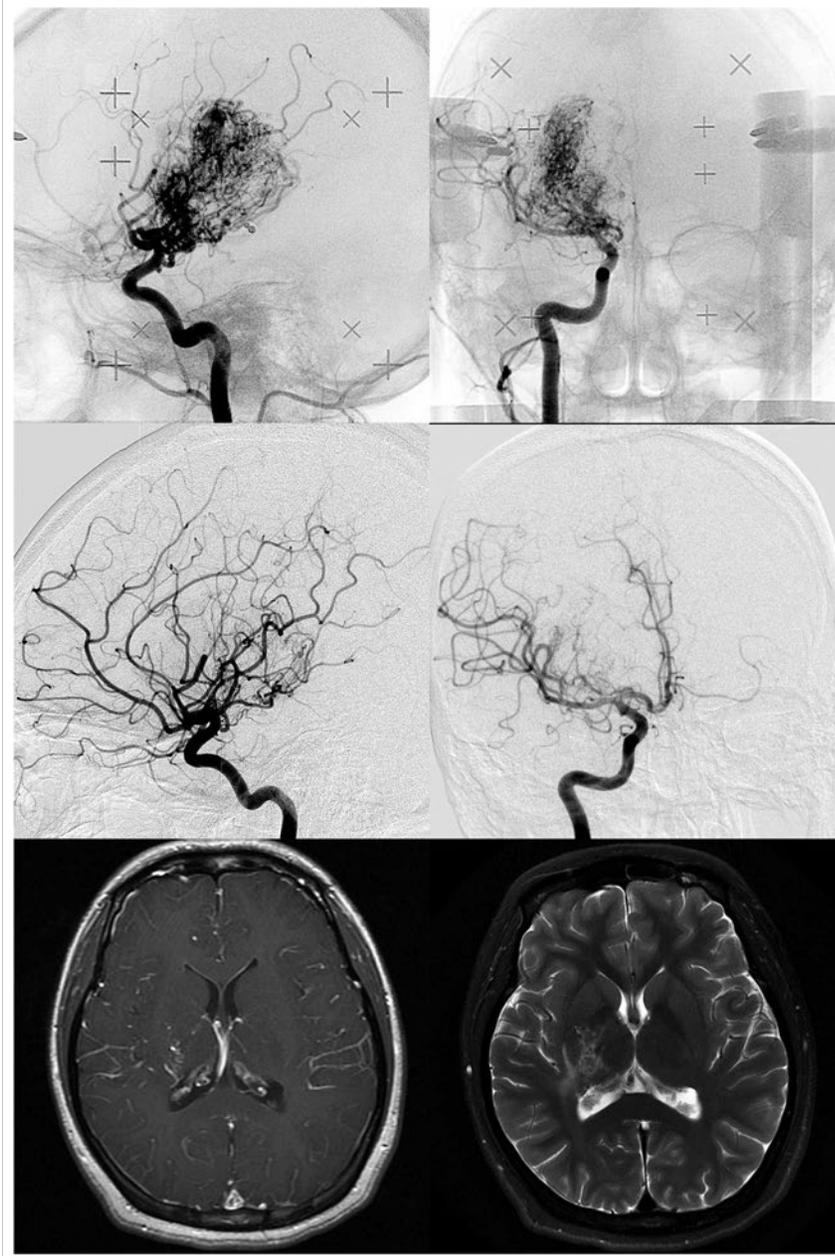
Upper: Angiograms showing a 12-year-old girl with a thalamic arteriovenous malformation at the time of Gamma Knife radiosurgery. Middle: Angiograms showing total obliteration 38 months after a second volume-staged radiosurgery. Lower: Axial T1-weighted contrast-enhanced and T2-weighted magnetic resonance images showing total obliteration with a slight abnormal area on the T2-weighted image.
